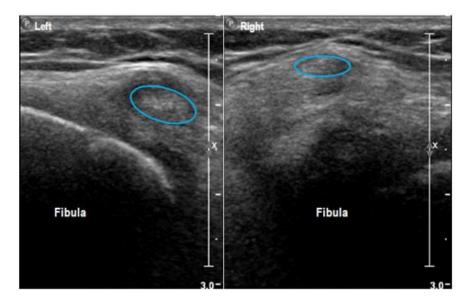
Ultrasound case 1: On the right side (pathological side) *n. fibularis communis* (blue) is denser en more hypoechoic than on the nerve on the left side (blue).
